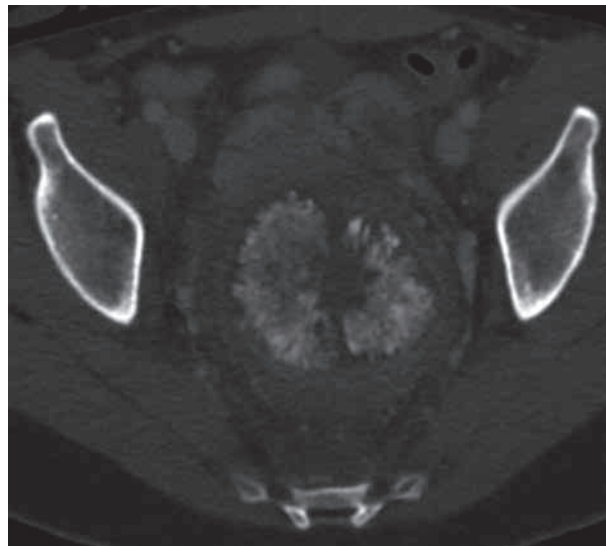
Axial contrast enhanced CT image (L : 800 HU ; W : 2000 HU) shows the calcified component of the rectal mass. Note the radial and organised disposition suggesting osseous matrix.
